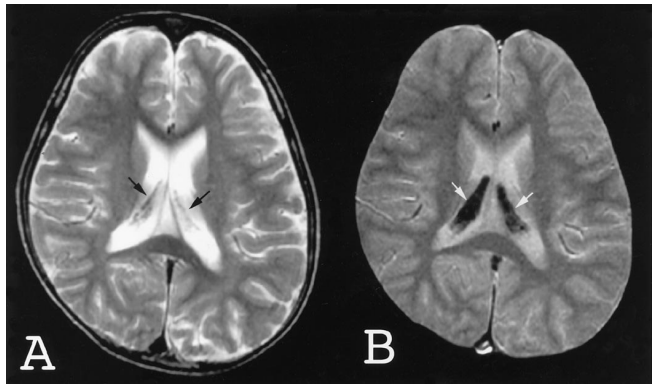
(A) Axial T2-weighted MRI shows decreased signal intensity over the bilateral choroid plexus (arrows). (B) A corresponding T2-weighted image reveals more decreased and widespread signal intensity (arrows). The choroid plexus appeared normal on T1-weighted imaging and CT scanning.*
